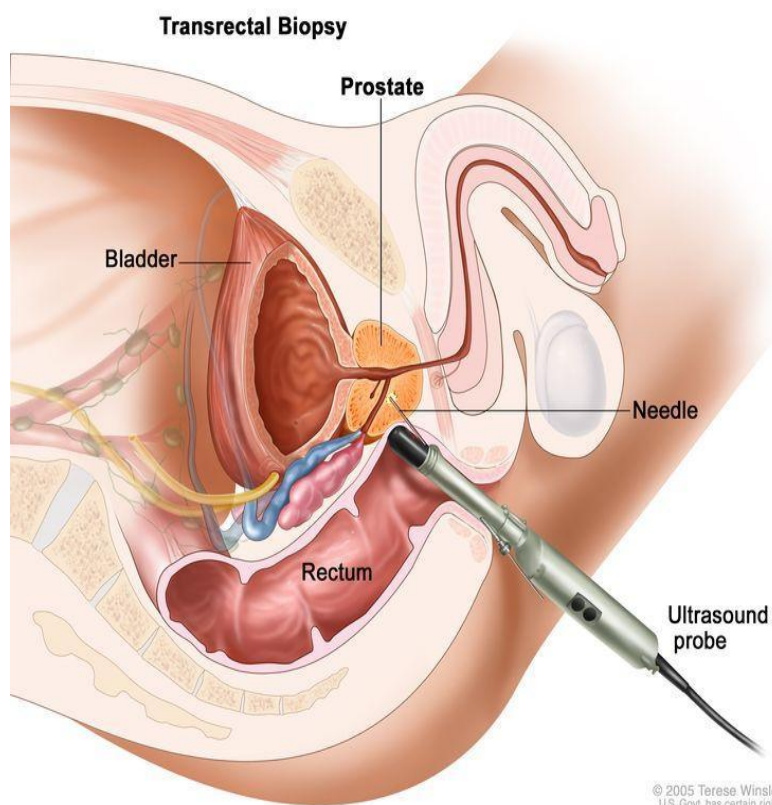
Transrectal biopsy; An ultrasound probe is inserted into the rectum to show where the tumor is. Then a needle is inserted through the rectum into the prostate to remove tissue from the prostate [21].
